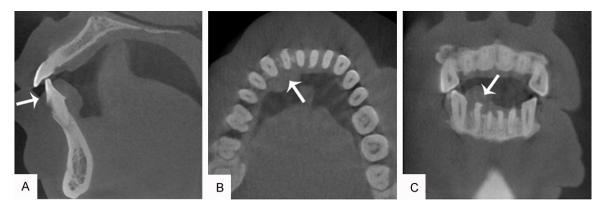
Radiographic results. CBCT showed a round nodule (Arrow) that is well-circumscribed and did not show associated bone involvement, as seen on the sagittal (A), axial (B) and coronal planes (C).
